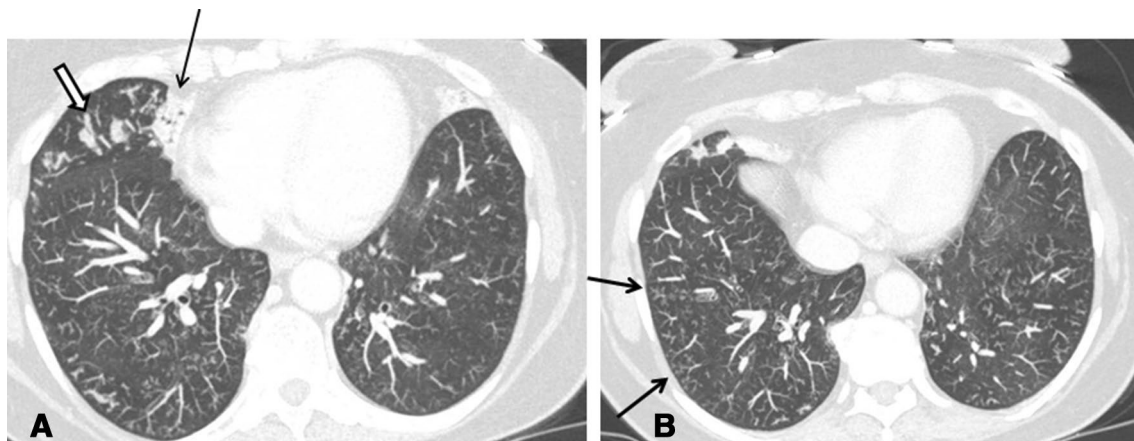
CT scans of a patient with NTM showing: a atelectasis (thin arrow), mucous plugs (thick arrow); b tree in bud opacities (thin arrows)
